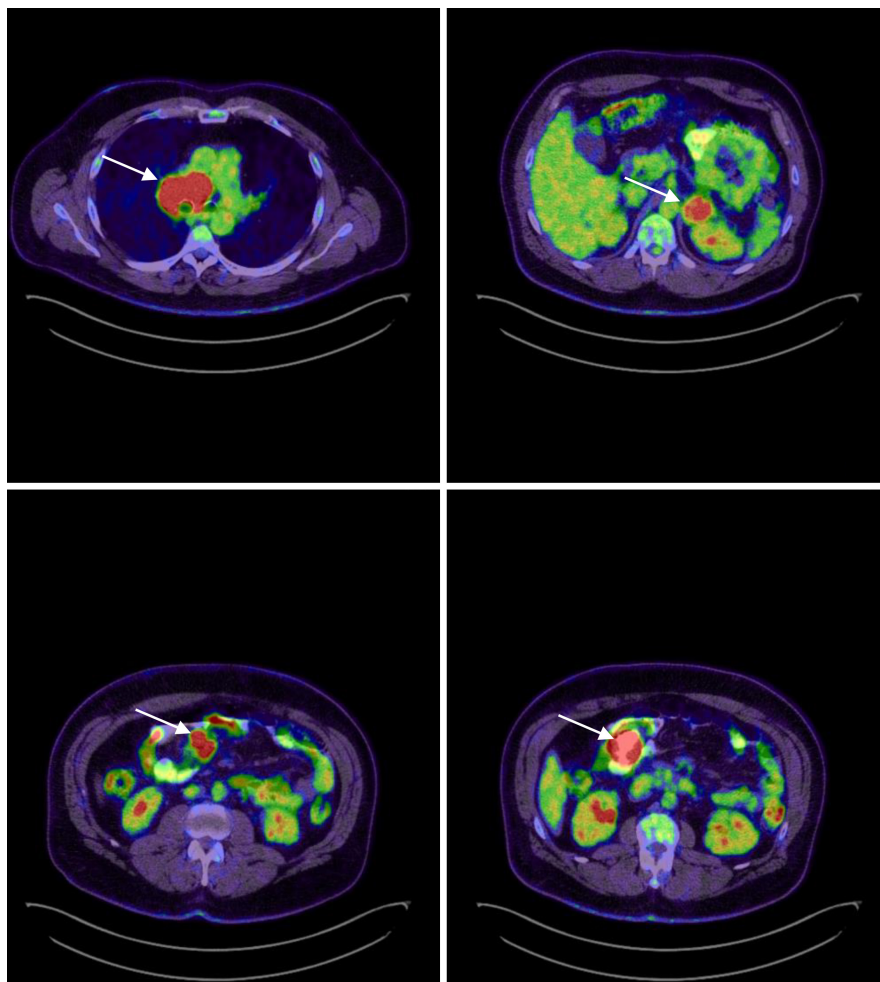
PET-CT scan showing hot uptake in different organs. Top left: Right hilar mass. Top right: Left adrenal mass. Bottom left: Mesenteric lymph nodes. Bottom right: Bowel mass.
